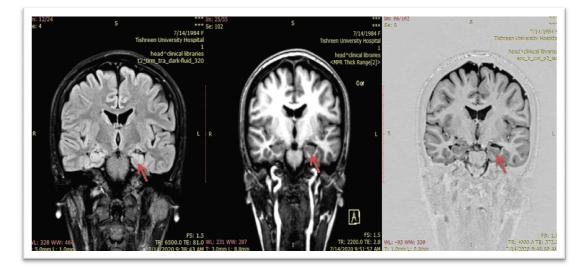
A 36-year-old female was clinically diagnosed with focal-onset seizure. FLAIR with coronal oblique plane, 3D acquisition isotropic T1, and 3D acquisition isotropic IR. There is increased signal with loss of volume of the left hippocampus (red arrow) suggestive of left mesial temporal sclerosis. Left temporal epileptiform discharges were recorded on EEG
